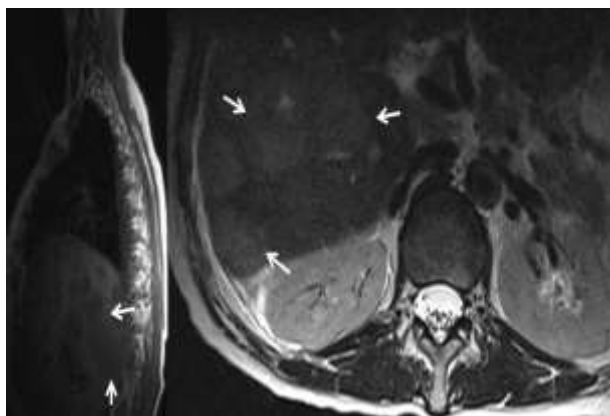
Liver metastatic solid lesions in sagittal localization and axial T2-weighted images in the liver of a 55-year-old woman.
